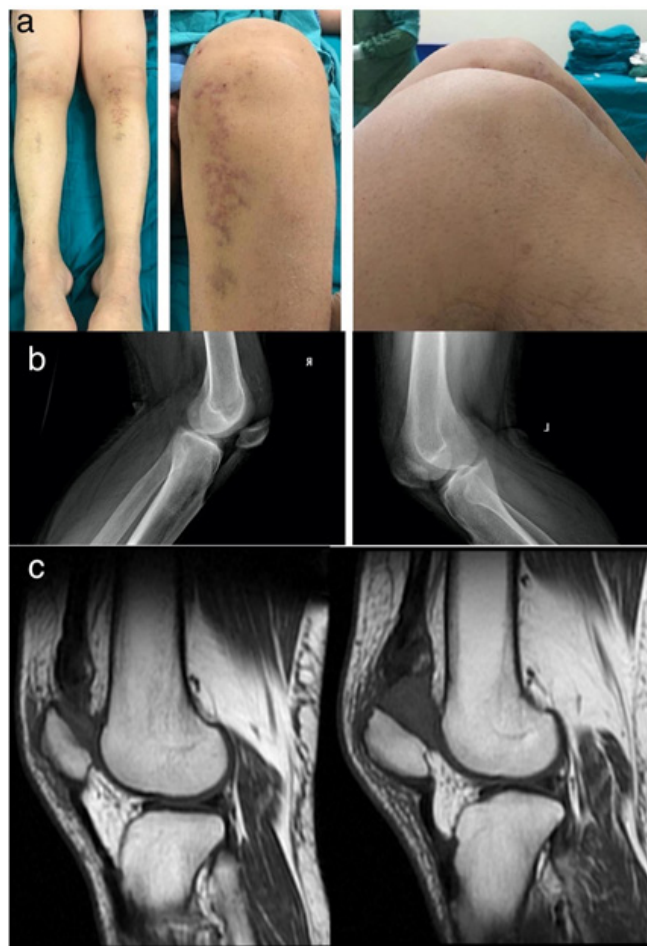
a: Preoperative clinical view of the knees at flexion, in which the gap formation can easily be seen as a groove at the superior border of the patella; b: X-rays of both knees preoperatively; c: Sagittal MRI views of both knees preoperatively.
